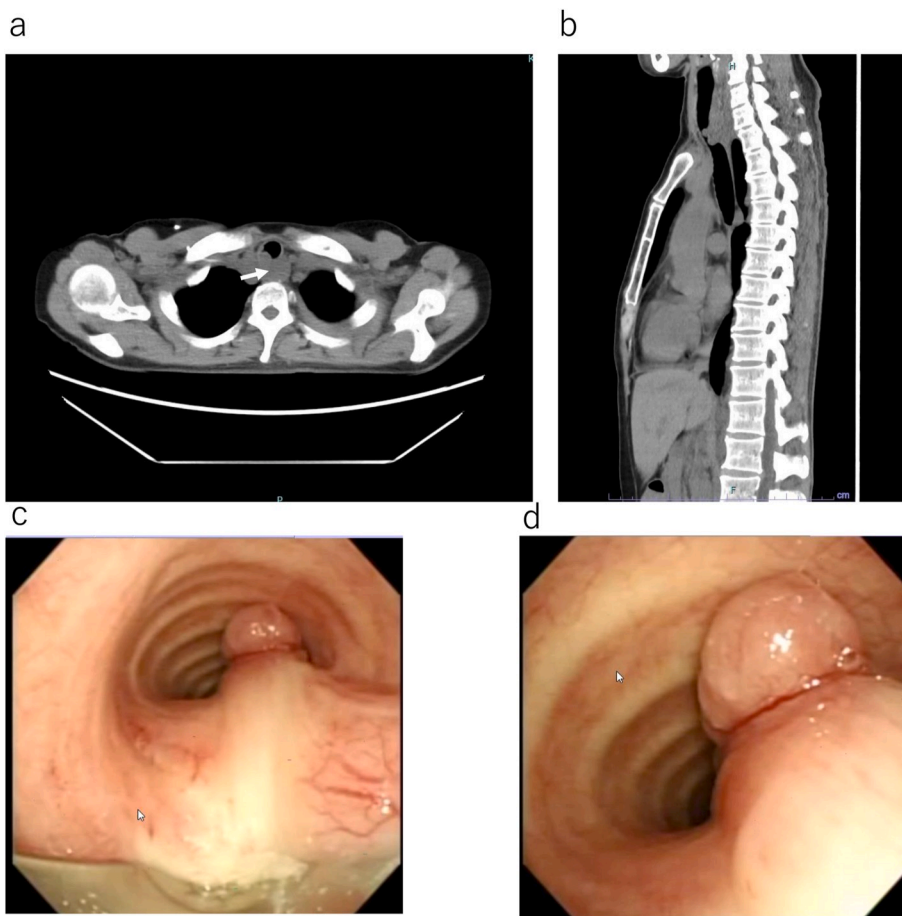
Computed tomography (CT) and endoscopic images obtained 8 months after the initial bronchial intervention. a. Horizontal section view of chest CT image. The border between the tumor and esophagus remains unclear and tumor invasion to the esophagus is also suspected (a white arrow). b. Sagittal section view. CT revealed that the size of the tumor had increased again. c. Endoscopic view. The tracheal lumen was narrowed by the tumor, and the endotracheal tumor was of mixed type.
